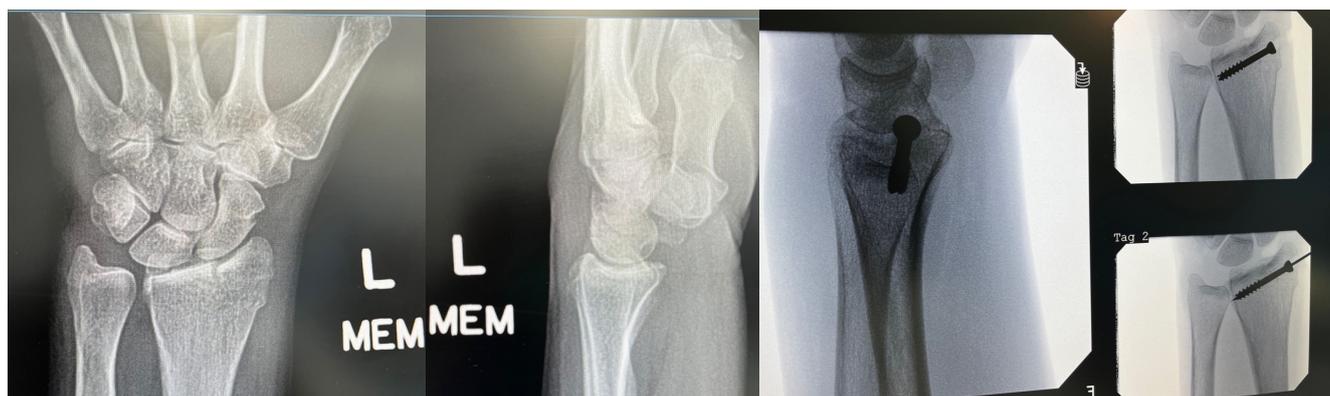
Preoperative radiographs showing an intraarticular distal radius fracture. Intraoperative radiographs showing arthroscopic-assisted reduction and screw fixation.
